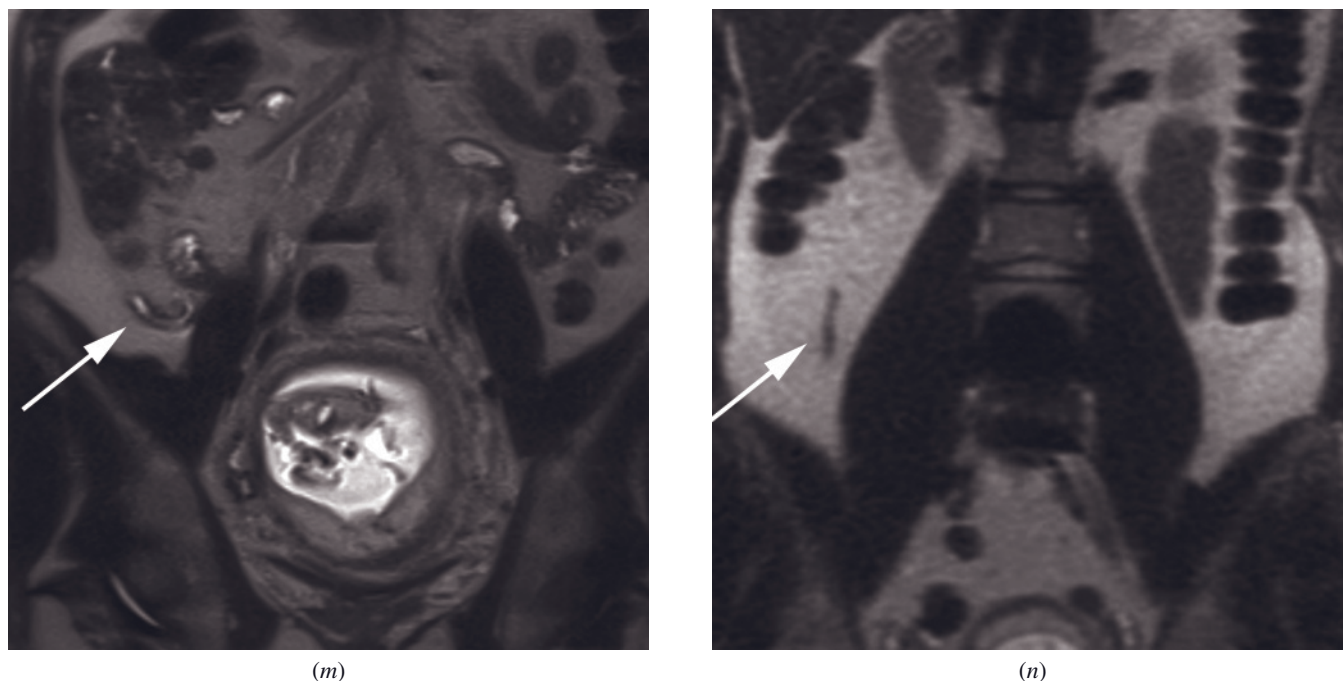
(Continued) acute appendicitis. The fluid-filled appendix is mildly dilated (arrows) with a small amount of periappendiceal fluid. Normal appendix (arrow, *n*) in a pregnant patient for comparison. Coronal T2-weighted SS-ETSE image shows a nondilated appendix with no adjacent inflammation.
